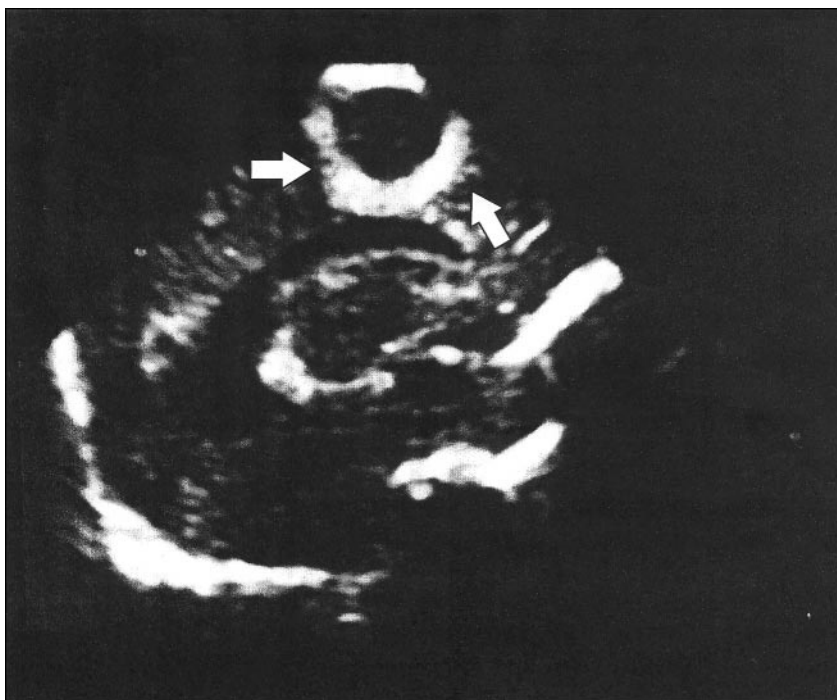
Cranial ultrasonography 1 week later of the echogenic abscess wall in the same patient as in Fig. 2 (arrows).
